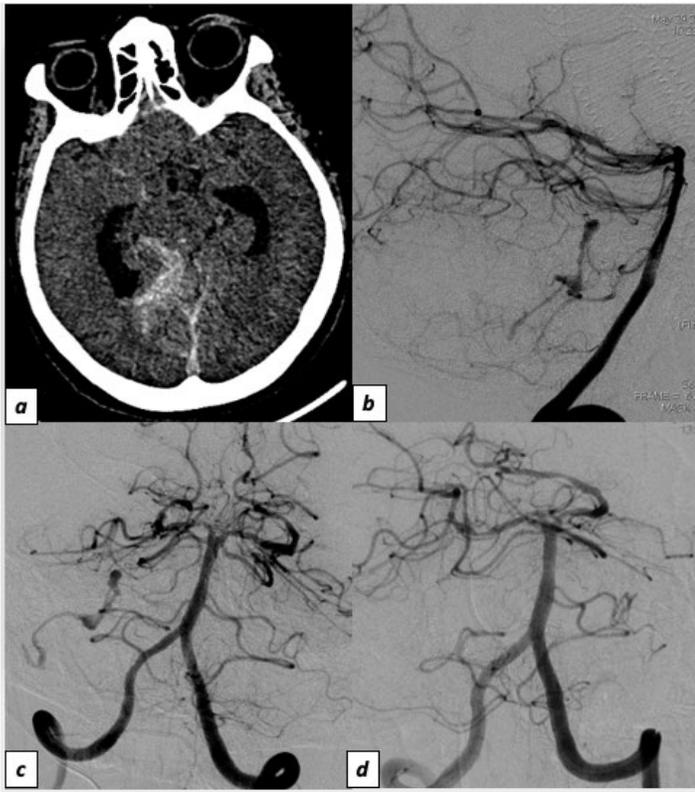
72 years old patient, loss of consciousness. (a): Non enhanced brain CT: subarachnoid hemorrhage. (b, c): Brain angiography in lateral (b) and frontal (c): stenosis of the right AICA with aneurysm of the homolateral artery. (d): Endovascular treatment in the same patient: embolization of the artery carrying the aneurysm by onyx with extinction of the aneurysm.
